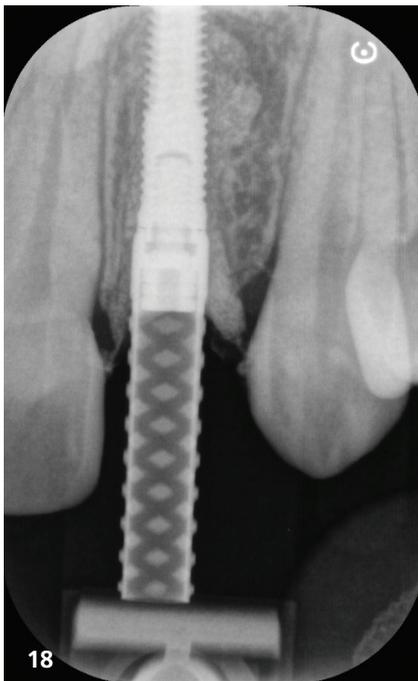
Immediate post-placement radiograph showing EthOss in both apical defect and jump gap.
